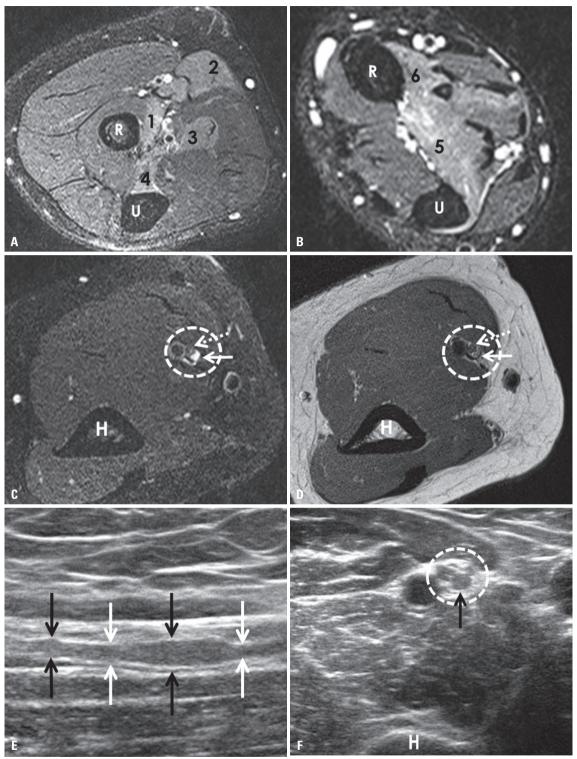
A 23-year-old man with incomplete constriction of the dorsal fascicle of the right median nerve and pseudo-AIN syndrome. (A) Axial FST2-weighted FSE image of the right elbow in the supine shows high signal intensities in the pronator teres (1), the flexor carpi radialis (2), some portions of the flexor digitorum superficialis (3), and the deep portion of the flexor digitorum profundus (4) muscles. (B) Axial FST2-weighted FSE image of the distal forearm shows high signal intensities within the pronator quadratus (5) and flexor pollicis longus (6) muscles. (C and D) Axial FST2-weighted (C) and proton-weighted (D) FSE images of the distal upper arm show a high signal intensity and enlargement of the dorsal fascicle (arrows) of the median nerve (dotted circle), corresponding to the fascicle that will form the AIN further distally. Note the normal, isointense signal intensity (dotted arrows) (relative to muscle) of remaining fascicular bundles of the median nerve (dotted circle). (E) Longitudinal ultrasonographic image of the median nerve at the distal upper arm level shows fusiform swelling (black arrows) and incomplete constriction (white arrows) of a fascicle of the median nerve. (F) On axial ultrasonographic image, the dorsal fascicle (black arrow) of the median nerve shows uneven swelling. AIN, anterior interosseous nerve; FS, fat-suppressed; FSE, fast spin echo; R, radius; U, ulna; H, humerus.
